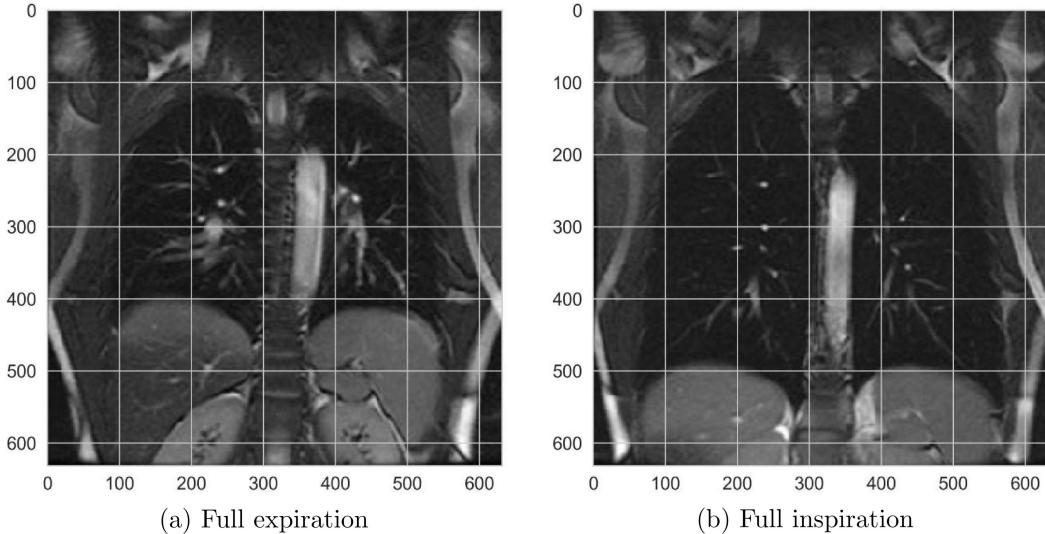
Pulmonary Ventilation components: full expiration and full inspiration at a 20 second duration interval is depicted in the MRI image.
